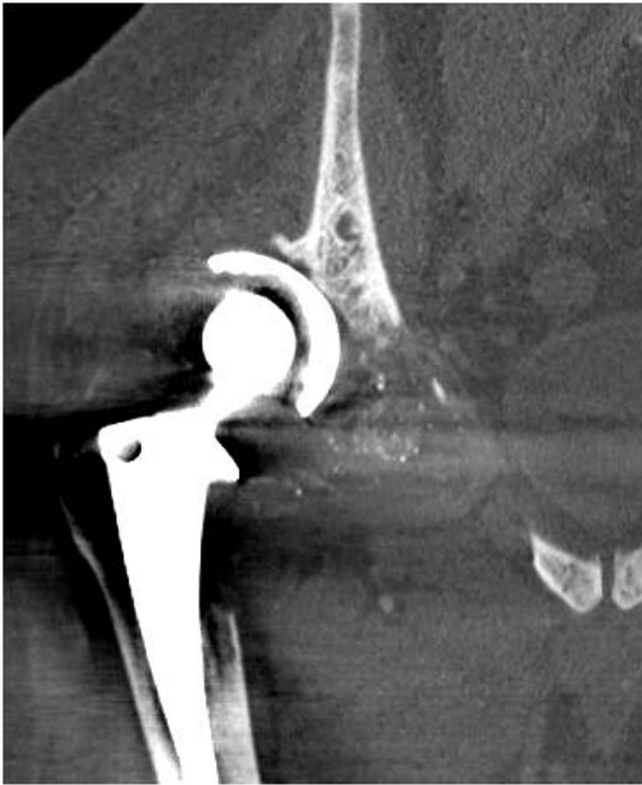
50-year-old man with extensive metallosis. Coronal reformatted CT of the pelvis without contrast in bone algorithm shows complete osteolysis of the right acetabulum with the space replaced by soft-tissue density and multiple foci of metallic debris, suggestive of advanced metallosis. The right femur is superiorly subluxated.
